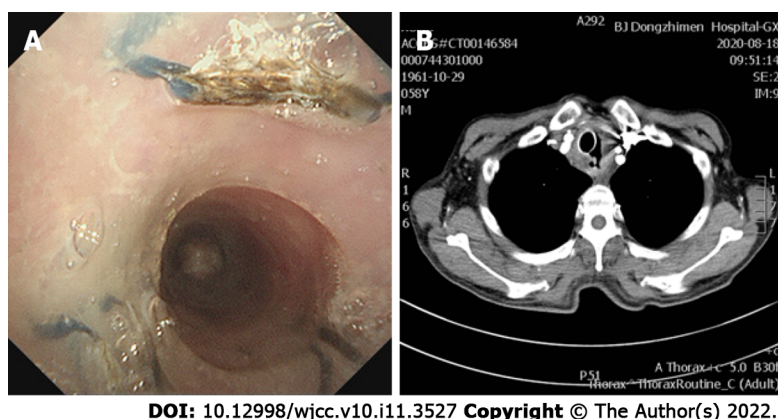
Original malignant tracheoesophageal fistula following rapid progression after the fourth dose of toripalimab. A: Bronchoscopy image; B: Computed tomography image showing the fistula having progressed.
